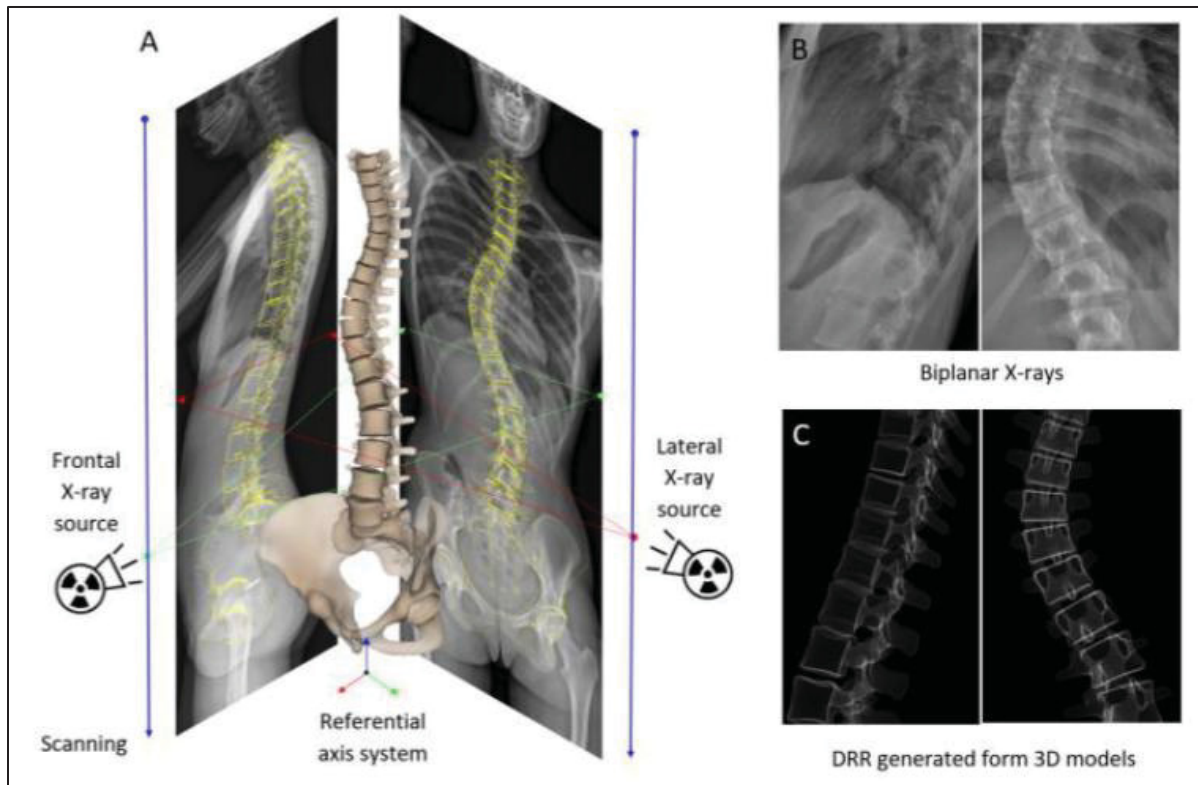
Biplanar X-rays from the spine vs. the DRR generated from 3D model
